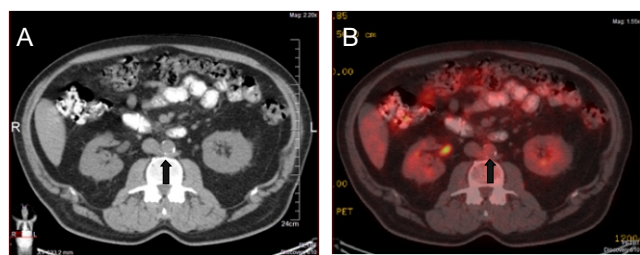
Axial plain CT (A) and fused PET/CT (B) images of RLRV (black arrows). Axial plain CT (a) and fused PET/CT (b) images of RLRV (black arrows).
